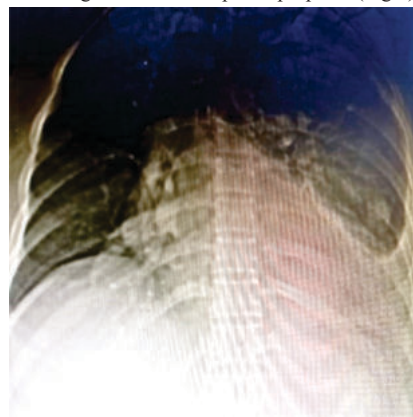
Chest X-ray done showed diffuse homogenous opacity in left lower zone with blunting of costo-phrenic angle. Malignancy and tuberculosis was kept as working diagnosis.
